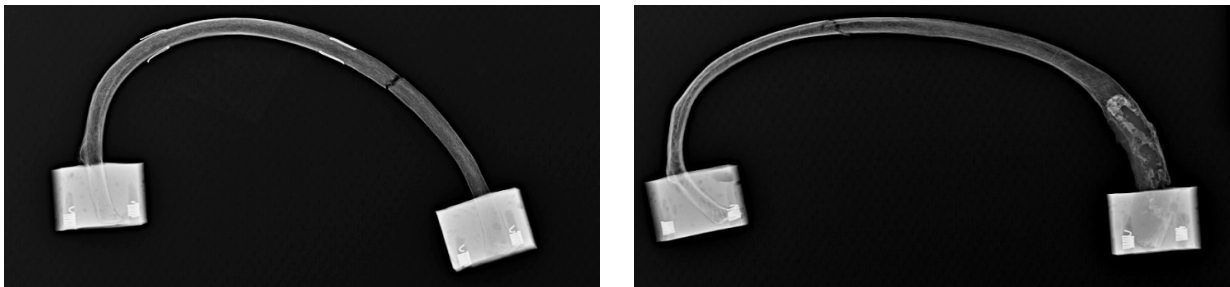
Pair 7 rib (left) and rib+CC (right) post-test x-rays (not to scale)
